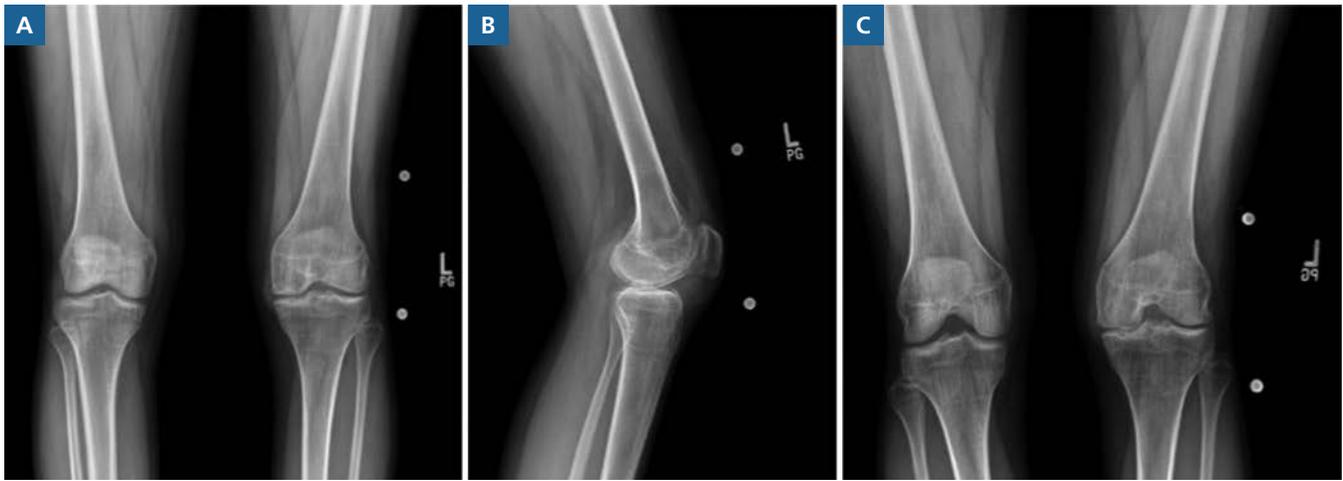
Pre- and post-cartilage restoration conventional radiographs of the patient's left knee. A, Anteroposterior view; B, lateral view; C, 45-degree oblique posteroanterior view, prerestoration; D, Alignment view, prerestoration, showing neutral alignment; E, F, One-year postoperative radiographs demonstrating excellent incorporation of the medial femoral condyle osteochondral allograft plug (A, anteroposterior view; B, lateral view).
